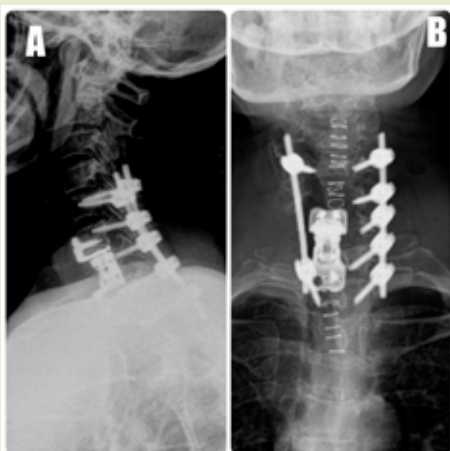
Post op X-ray. A & B - Lateral & Antero posterior X-ray of Cervical spine.
